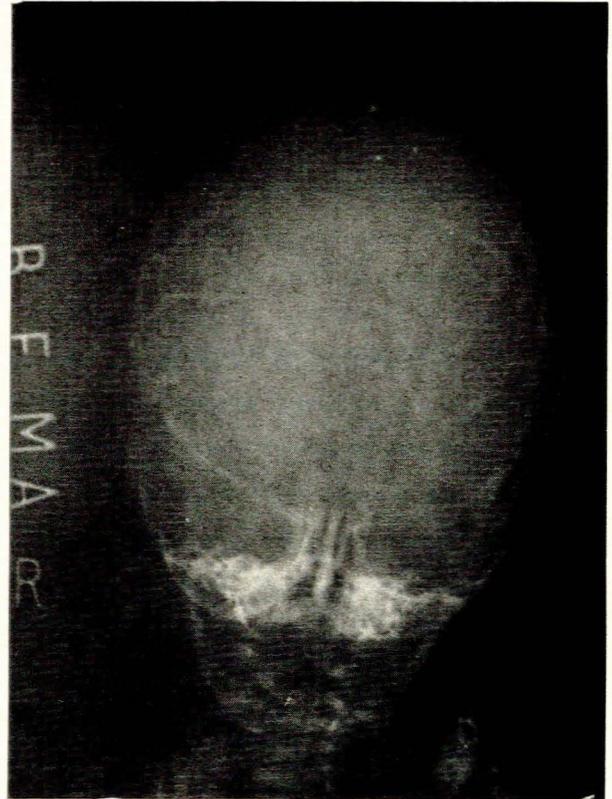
Radiographs of the skull.
